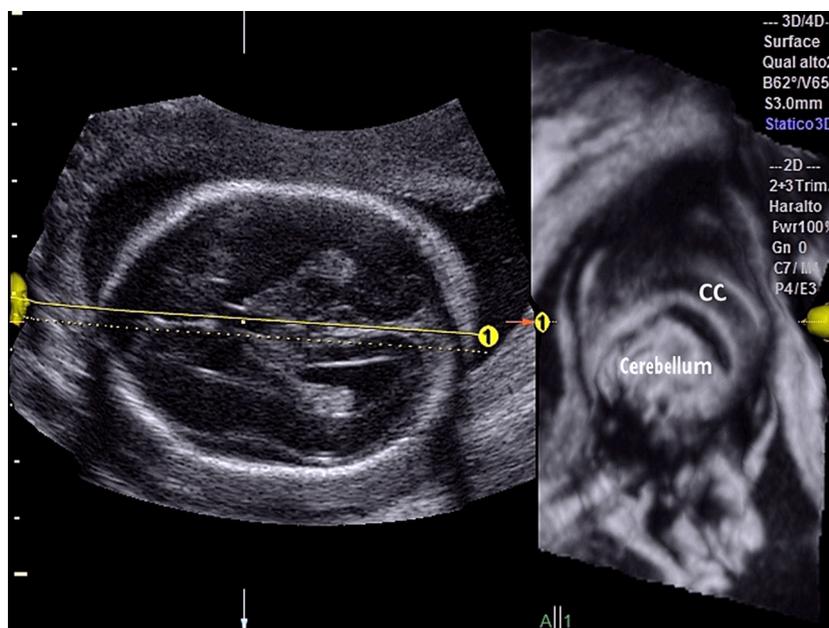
Fetal neurosonogram using Omniview: Reconstruction of the corpus callosum (CC) in a normal fetus at 20 wk of gestation.
